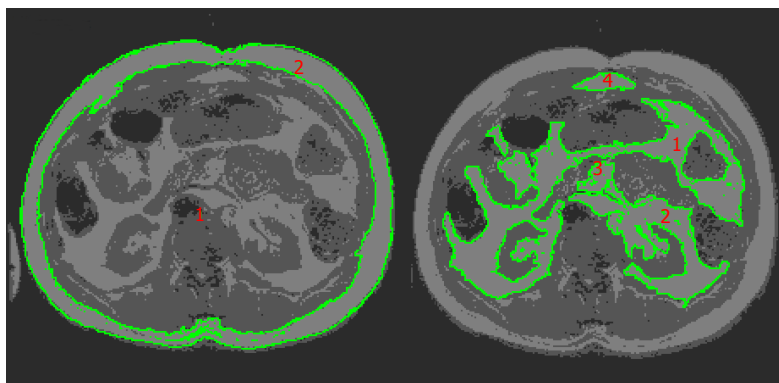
A representative magnetic resonance imaging analysis of subcutaneous and visceral adipose tissues in a person with spinal cord injury. Note the tracing of visceral adipose tissue within the region of interest. The numbers 1, 2, 3 and 4 refer to the visceral fat (VAT) cross-sectional areas of disconnected regions. These 4 regions are later summed to have the total VAT area in the entire region. VAT: Visceral adipose tissue.
